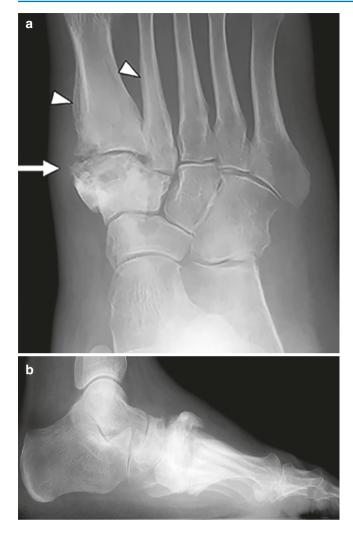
Hypertrophic form of neuroarthropathy. (a) AP and (b) lateral radiographs show hypertrophic changes in the medial midfoot (arrows), centered about the tarsometatarsal joint. There is bony proliferative change, increased density and non-aggressive periosteal new bone formation (arrowheads) in the 1st and 2nd metatarsal bones, and increased density in the corresponding cuneiforms. In its early phase, this form of neuroarthropathy may be confused with osteoarthritis. Note soft tissue swelling, with effacement of fat planes
